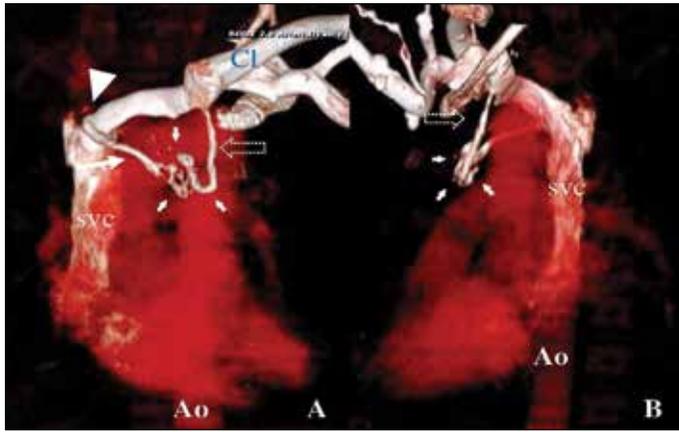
Chest computed tomography three-dimensional images of well-defined venous malformation with moderate contrast from different perspectives
